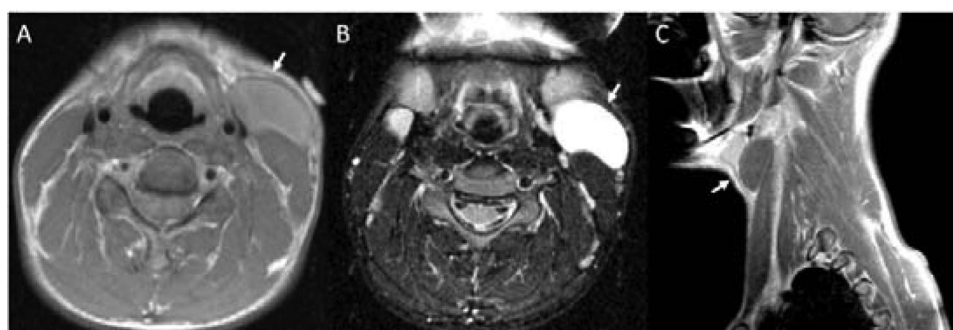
Axial T1-weighted (A), axial fat-suppressed T2-weighted (B), and sagittal T1-weighted (C) MR images of a child with a Bailey type II second branchial cleft anomaly. The images demonstrate a well-defined, thin-walled cystic structure situated in the lateral neck. The axial images (A, B) demonstrate the classic location of the cyst lateral to the carotid space. The sagittal image (C) shows the other classical location landmarks of the cyst, positioned along the anterior surface of the sternocleidomastoid muscle and posterior to the submandibular space.
